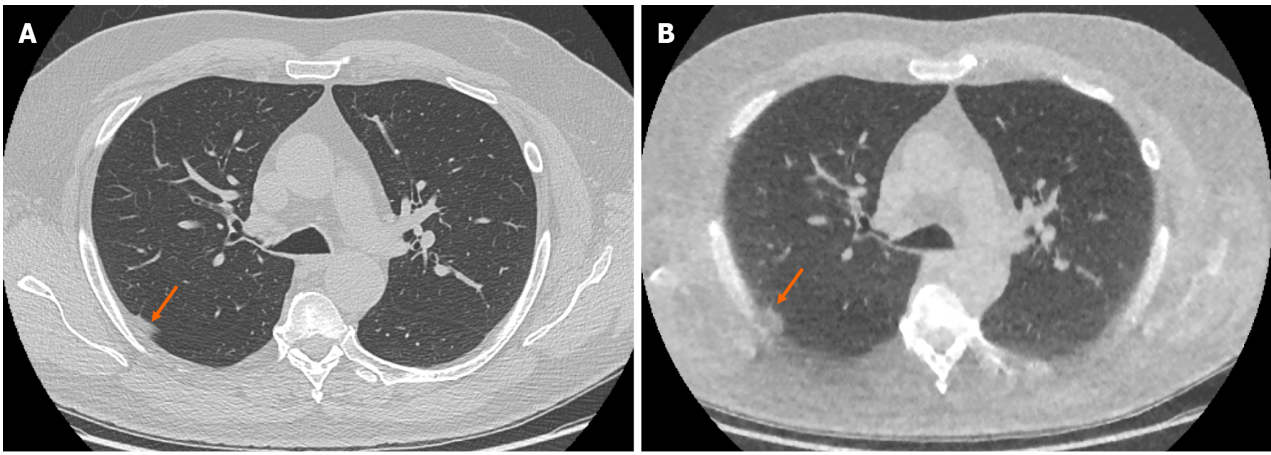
Example of false positive pulmonary nodule identification on ultra-low-dose computed tomography chest. A: Selected axial slice of a standard dose computed tomography (CT) chest presented in lung windows with a small focus of peripheral atelectasis in the posterior segment of the right upper lobe (arrow); B: Selected axial slice of an ultra-low dose CT chest with model-based iterative reconstruction presented in lung windows at the same level in the same patient with the focus of soft tissue attenuation in the posterior segment of the right upper lobe incorrectly identified as a solid pulmonary nodule (arrow). The incidence of false positive solid nodule identification was minimal and did not reach statistical significance.
